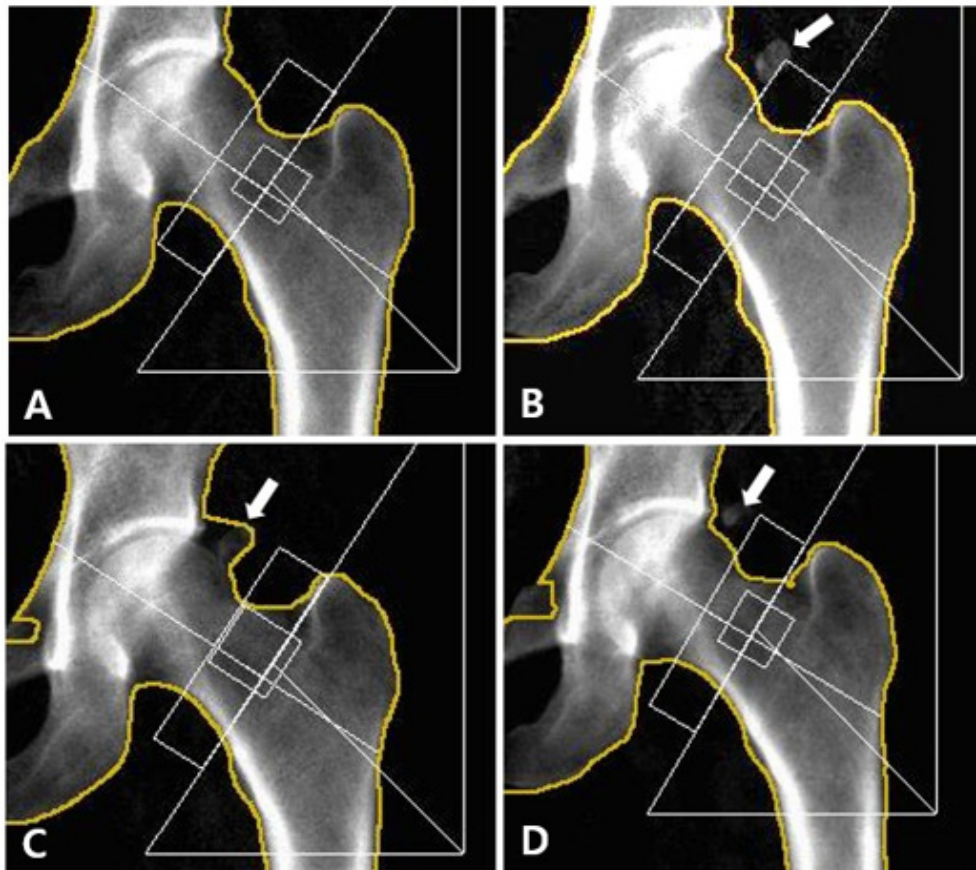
Serial left hip dual-energy X-ray absorptiometry (DXA) images obtained annually from 2023 to 2026. Baseline DXA image obtained in 2023 showing no calcific lesion around the left acetabulum (A). DXA image obtained in 2024 showing a newly developed calcific lesion (arrow) at the superolateral aspect of the left acetabulum (B). DXA image obtained in 2025 showing the calcific lesion (arrow) included within the automatically generated region of interest (ROI) during bone mineral density analysis (C). DXA image obtained in 2026 showing the calcific lesion (arrow) manually excluded from the ROI before bone mineral density analysis (D).
